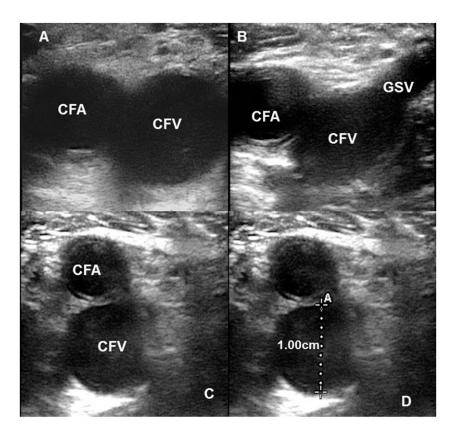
Ultrasound images of the right femoral vein scanning caudally from the inguinal ligament. (A) Transverse image of the common femoral artery (CFA) and vein (CFV) at the inguinal ligament. (B) Junction of the great saphenous vein (GSV) with the CFV. (C) CFV just distal to the point where the GSV disappeared. This is the point at which femoral vein diameter (FVD) was measured. (D) FVD was measured as the maximum anterior (A)-posterior dimension using the leading edge technique.
